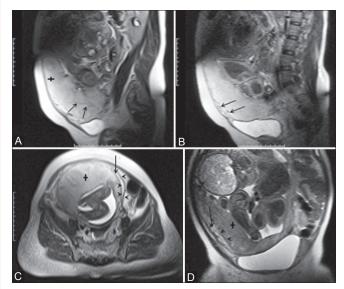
(A-D): Marginal placenta previa in a 32-year-old woman at 35 weeks of gestation. (A) Sagittal T2 HASTE MR image shows a homogeneous placenta (+) with thin linear areas of decreased signal intensity (arrows) representing normal placental septa. (B) Sagittal T2 HASTE MR image shows normal subplacental vascularity (arrows) appearing as small hypointensities underneath the placenta. (C, D) Axial and coronal T2 HASTE MR images show a homogeneous placenta (+) and triple-layered appearance of normal myometrium – peripheral thin hypointense bands (arrowheads) and thickened vascular hyperintense middle layer (arrow)
